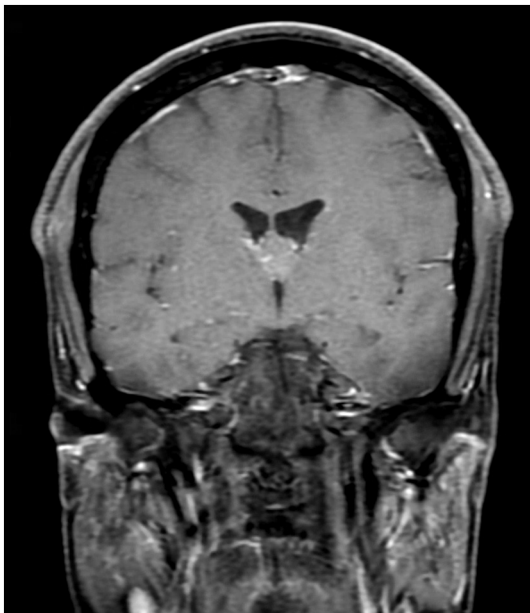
MRI colloid cyst - coronal T1 sequence.
